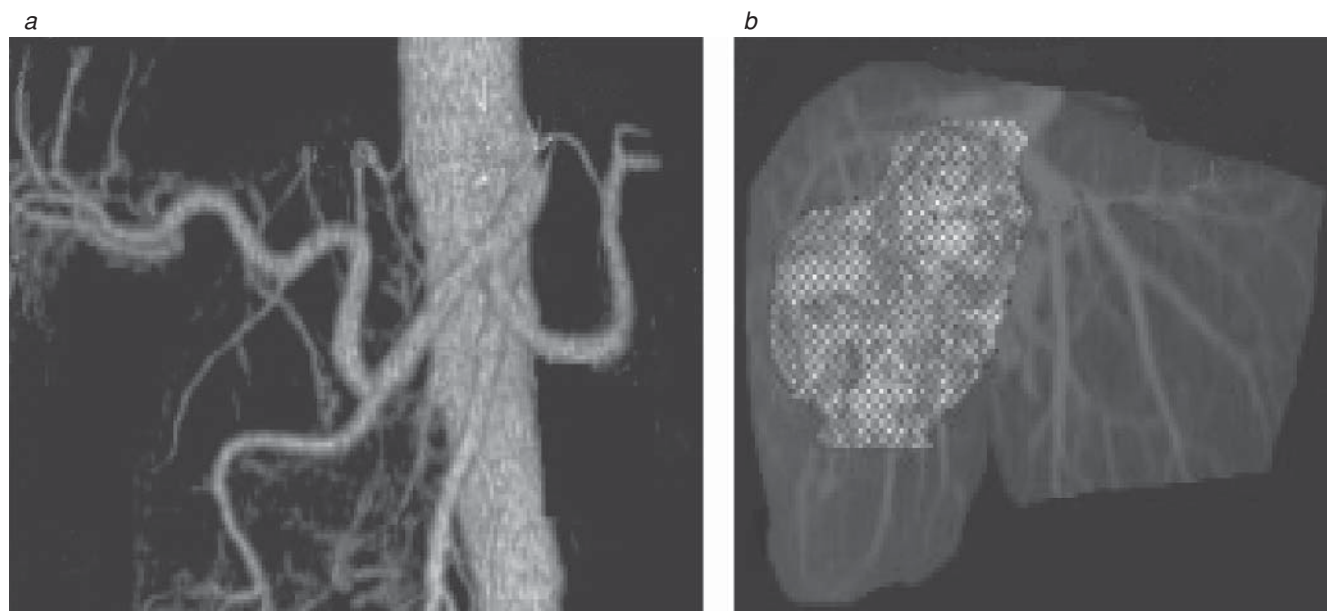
(a) The arterial anatomy of the celiac axis is reconstructed from thin-slice computed tomographic images. (b) The hepatic venous anatomy is similarly reconstructed, with the tumor superimposed on the vascular reconstruction.
